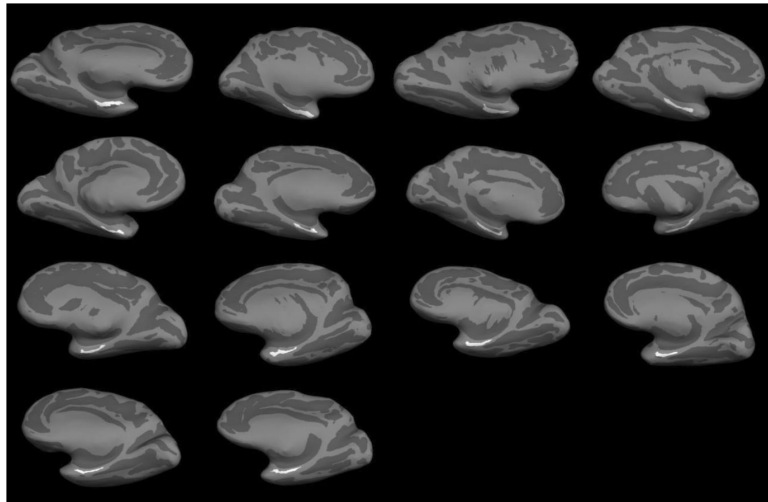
Fourteen cases were labeled on high resolution *ex vivo* MRI volumes and mapped to respective individual surface maps. Each inflated brain shows the location of perirhinal cortex (area 35) for each case labeled in white.
